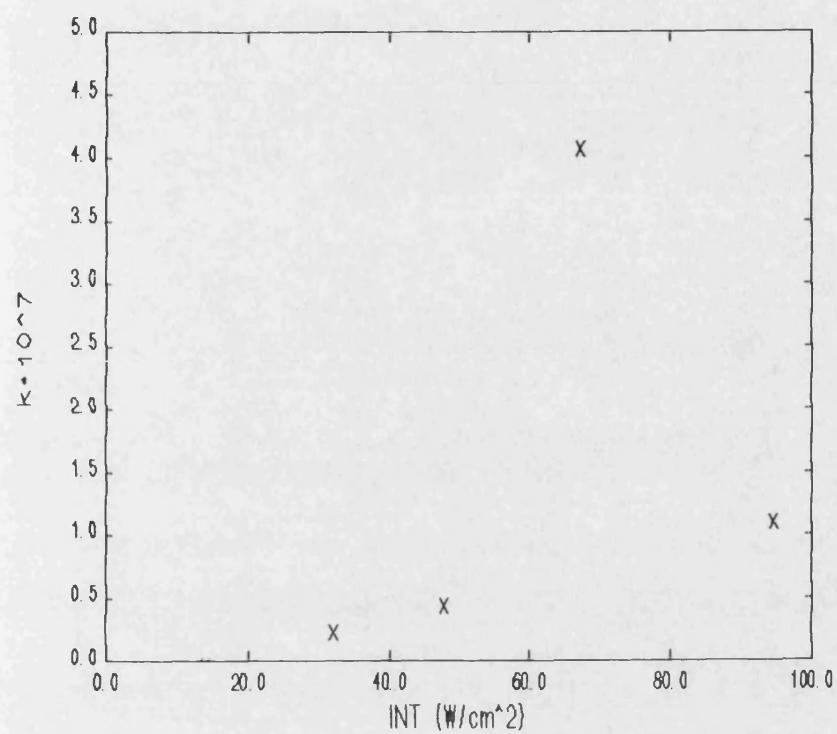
Effect of ultrasonic intensity on the Overall rate constant
